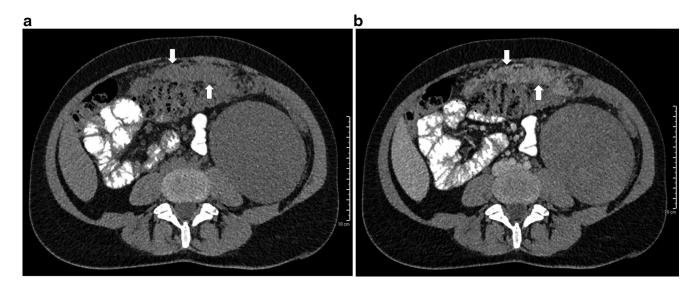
CT scan of the abdomen and pelvis demonstrates multiple lobulated iso to hypodense coalescent peritoneal nodules with moderate enhancement. White arrows: peritoneal nodules.
